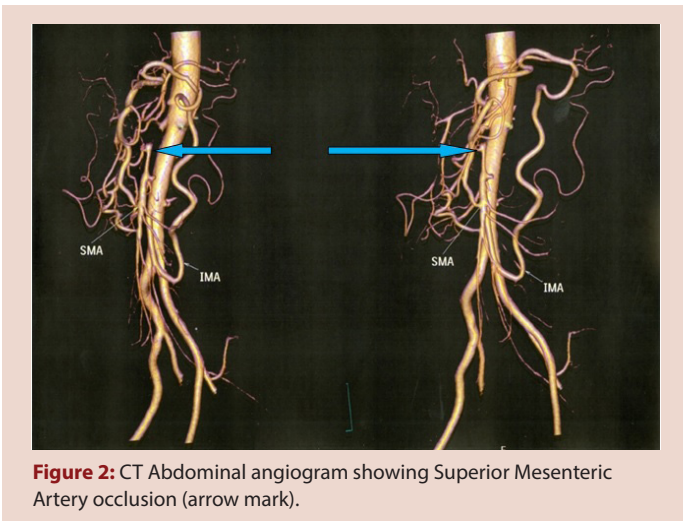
CT Abdominal angiogram showing Superior Mesenteric Artery occlusion (arrow mark).
